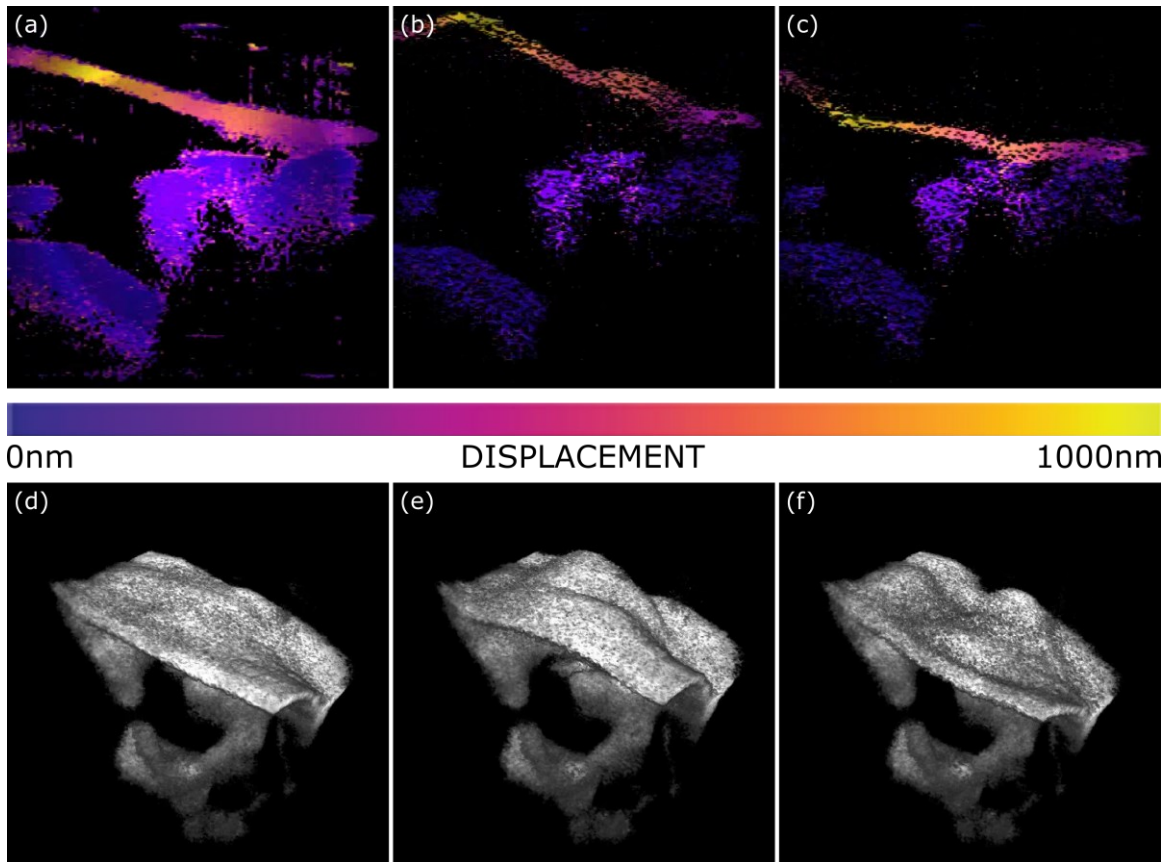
Cross-sectional and Volumetric animation of a ME-OCT Doppler vibrometry dataset of an ex-vivo middle ear cadaver model acquired at a stimulus frequency of 500 Hz with a nominal pressure of 100 dB SPL. (a) Cross-sectional view of a central slice from the ME-OCT Doppler vibrometry dataset with a false colour associated with vibrational amplitude displacement overlaid. (b) Snapshot of the cross-sectional animation when the TM vibrational amplitude is at its positive peak. (c) Snapshot of the cross-sectional animation when the TM vibrational amplitude is at its negative peak. (d) Volumetric render of the ME-OCT Doppler vibrometry dataset before animation. (e) Snapshot of the volumetric animation when the TM vibrational amplitude is at its positive peak. (f) Snapshot of the volumetric animation when the TM vibrational amplitude is at its negative peak. From [1]. Videos of both the cross-sectional and volumetric Doppler animation can be found in Supplementary File C and Supplementary File D respectively. Adapted with permission from [1] © Optical Publishing Group.
